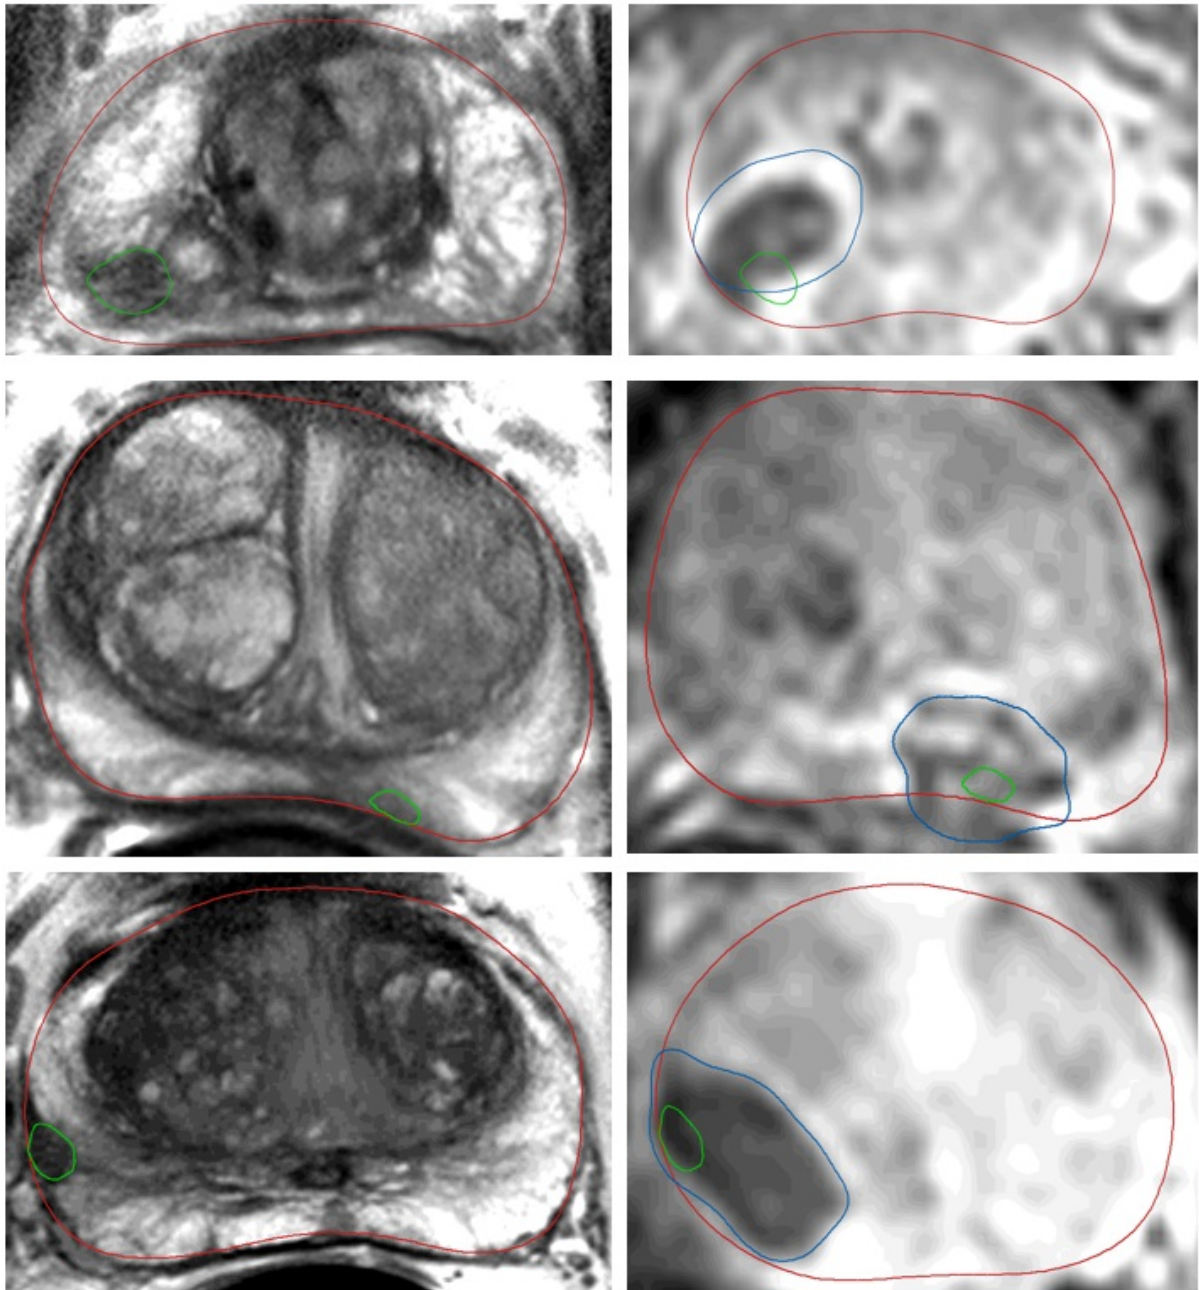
Slices of registered tumour (green), ablation zone (blue), and prostate boundary (red) overlayed on MRI. Each row is a different patient. Images in the left column are pre-operative T2 images, and images in the right column are DCE images. The tumour in the top row was partially ablated, and the tumours in the second and third rows were completely ablated.
